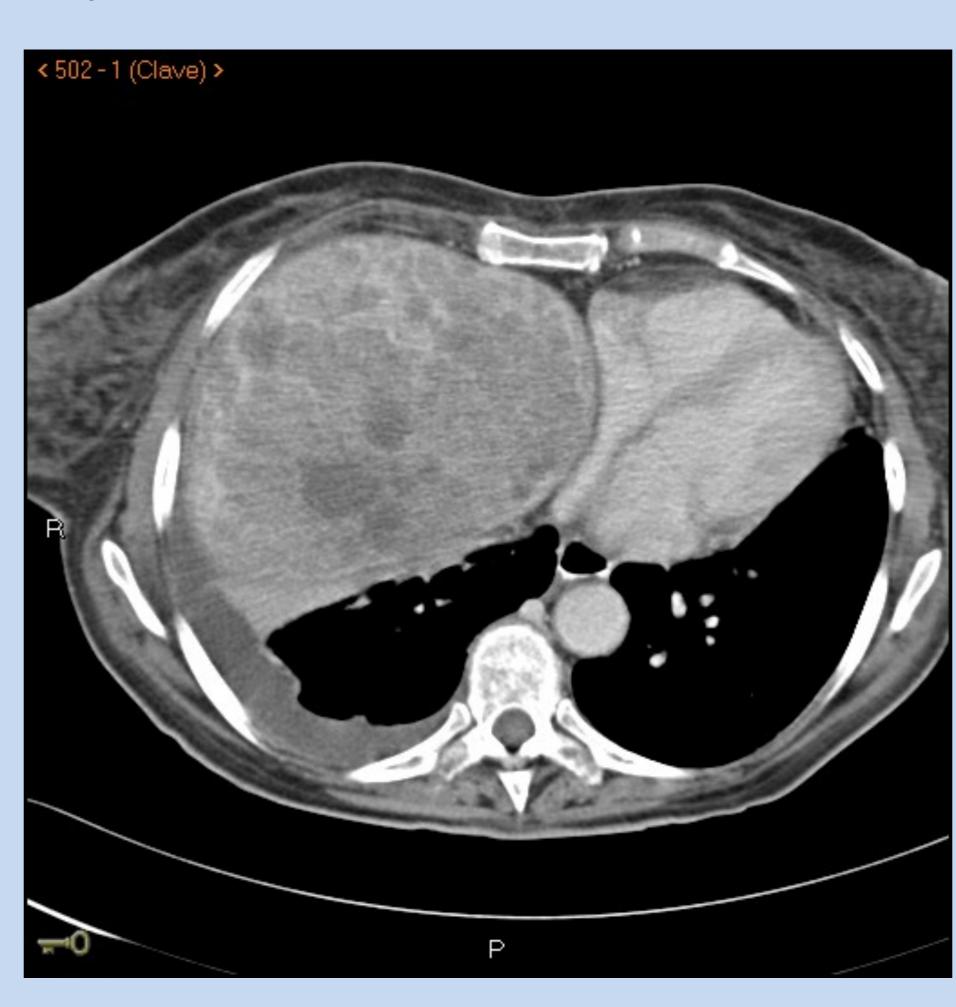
High-resolution CT scan image, showing compression of right atrium by a huge nodular liver.
